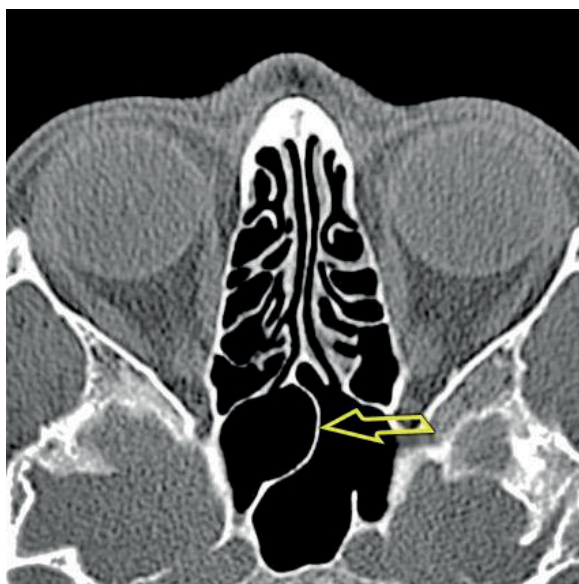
A CT scan of the paranasal sinuses, transverse plane. The main septum in the shape of the inverted letter 'C.'
